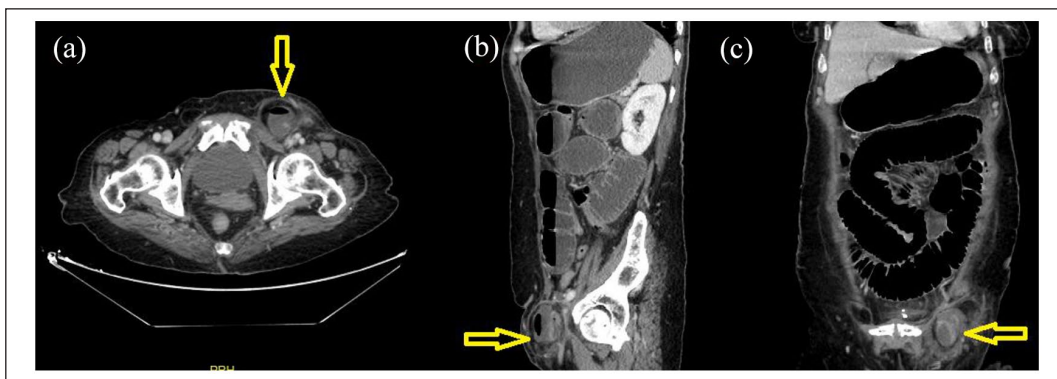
CT abdomen showed femoral hernia (yellow arrow).
